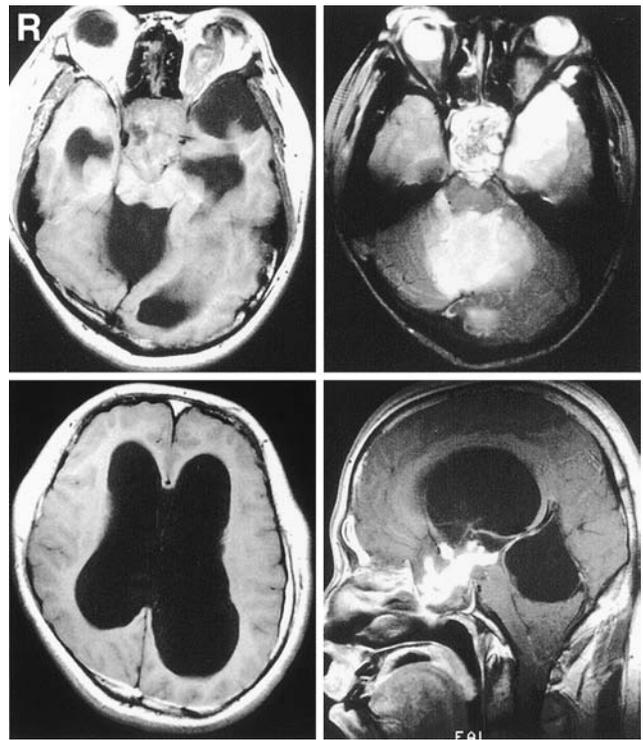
Axial T₁-weighted (upper left) and T₂-weighted (upper right) magnetic resonance (MR) images on admission showing the tumor extended intra- and suprasellarly with inhomogeneous intensity, and an arachnoid cyst in the left middle fossa. T₁-weighted MR image (lower left) showing marked enlargement of lateral ventricles. Sagittal T₁-weighted MR image (lower right) demonstrating an arachnoid cyst in the infratentorial supracerebellar space, and the cerebellar tonsils herniated into the foramen magnum due to compression by the arachnoid cyst.
